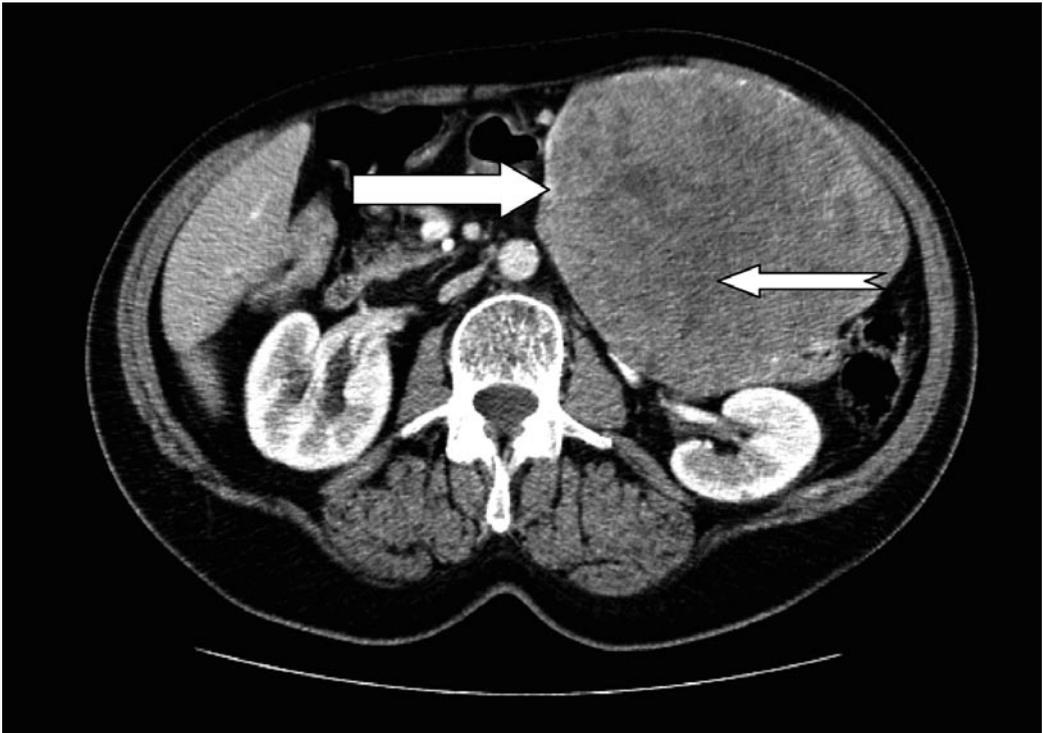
Abdominal CT post-contrast axial scan. Large round expansive mass in the upper abdomen with heterogeneous structure sharply demarcated from surrounding structures depicted on this scan. Higher attenuation coefficients on periphery (white arrow) and lower in the central part were detected on native and postcontrast scans (white notched arrow).
